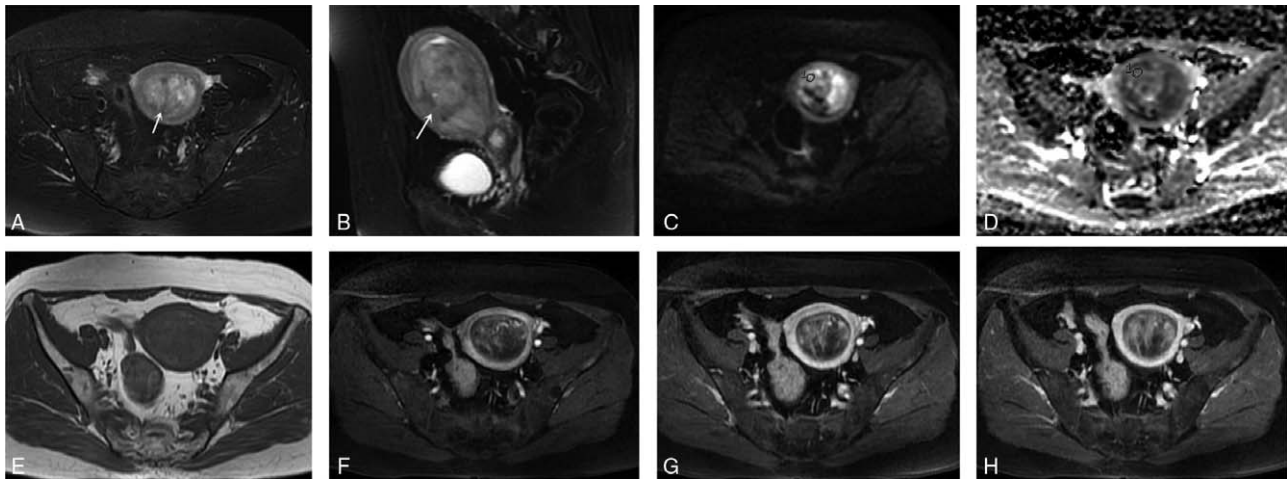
A 58-year-old woman with ESS confirmed by surgery and pathology. (a, b) Axial and sagittal T2-weighted image indicated the mass was major located in the uterine cavity with band sign (white arrows). The lesions showed mixed signal with patchy cystic change or necrosis (hyperintensity on T2-weighted image and hypointensity on T1-weighted image). (c) Axial diffusion-weighted imaging showed hyperintensity in the solid component of tumor. (d) Axial ADC map revealed the solid component of ESS showed restricted diffusion, and the mean ADC, minimum ADC, and rADC values were $1.12 \times 10^{-3} \text{mm}^2/\text{s}$, $0.80 \times 10^{-3} \text{mm}^2/\text{s}$, 0.74 respectively. (e) Axial T1-weighted image revealed the solid component of ESS showed slight hyperintensity. (f-h) Axial contrast-enhanced magnetic resonance imaging including arterial phase, venous phase, and delayed phase, and ESS displayed mild and delayed enhancement. ESS=endometrial stromal sarcoma, ADC=apparent diffusion coefficient, rADC=lesion-muscle ADC ratio.
